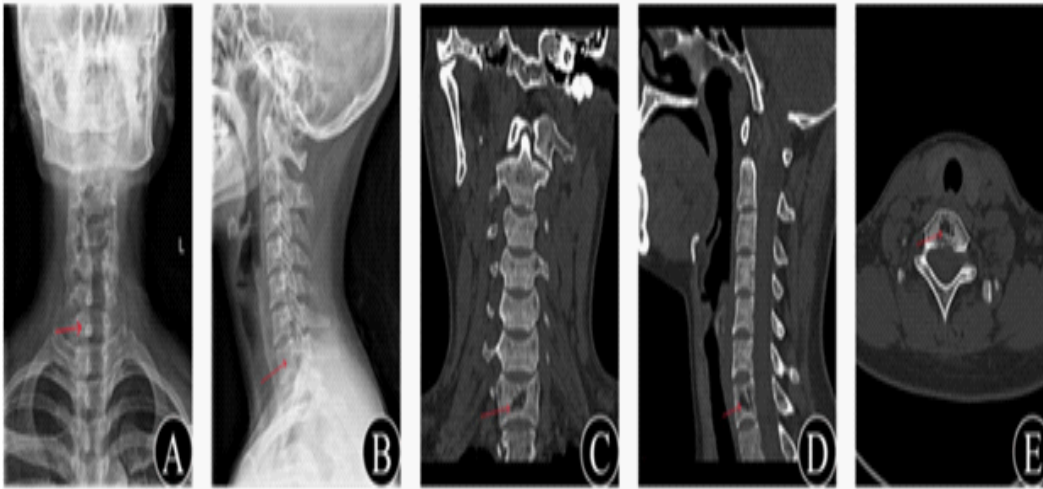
(A,B) X-ray of the cervical spine showed abnormal C7 transmittance in the anterolateral position. (C-E) CT of the cervical spine showed C7 irregular hypodense shadows, and strip-like hyperdensities were seen in them, showing a “fence sign”.
